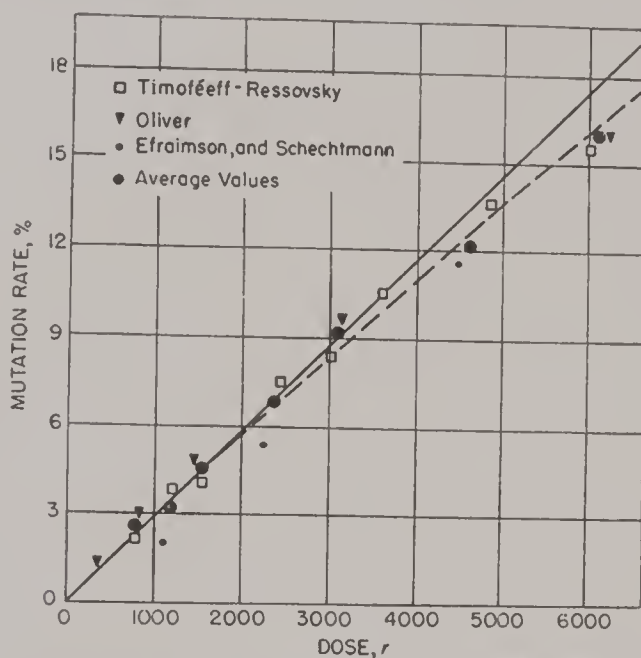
The solid line reveals the direct proportionality of rates of sex-associated mutations in *D. melanogaster* to dose of x-rays. The effect of the saturation curve on the direct proportionality is indicated by the dotted line. Observed points are by various authors, as listed.
